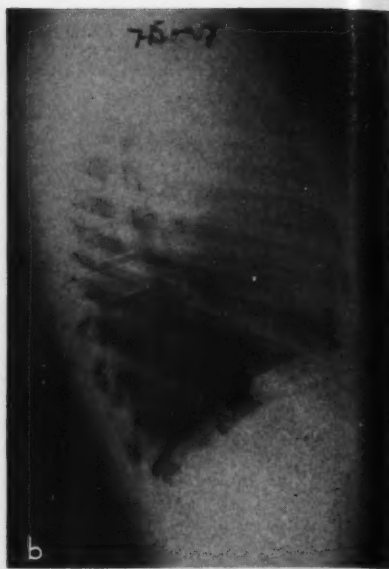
Chest X-rays of an 11 year old white male with a diagnosis of lymphosarcoma confirmed by lymph node biopsy.
